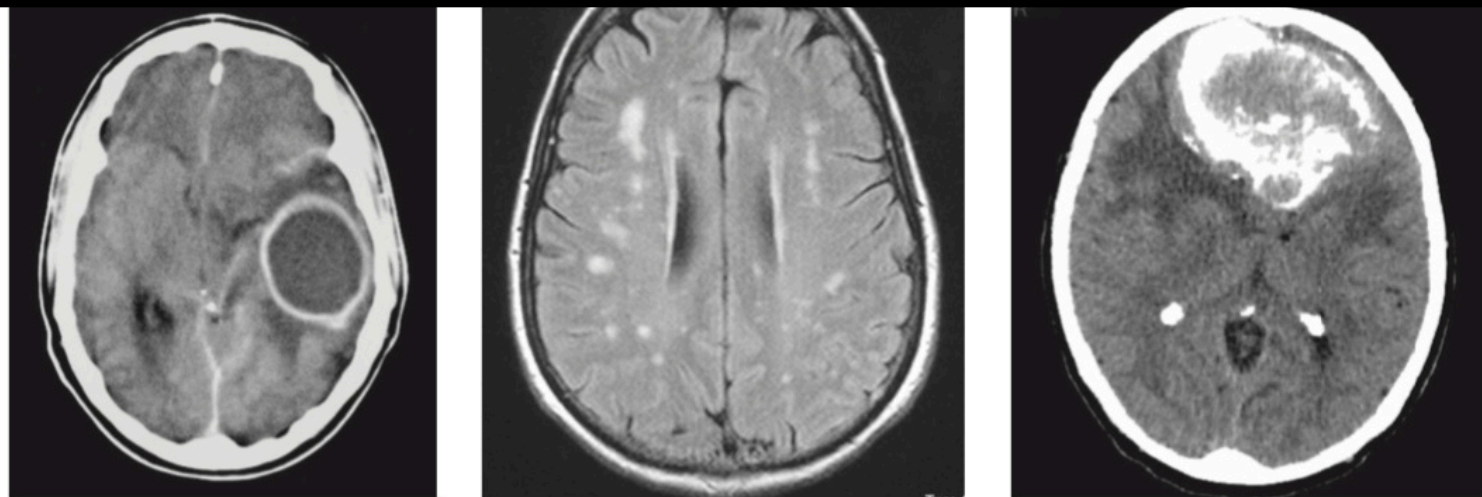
Imaging of the head. A Computed tomogram (CT) showing a cerebral abscess. B Magnetic resonance scan showing multiple sclerosis with white demyelinating plaques. C CT scan showing a large meningioma arising from the olfactory groove.
